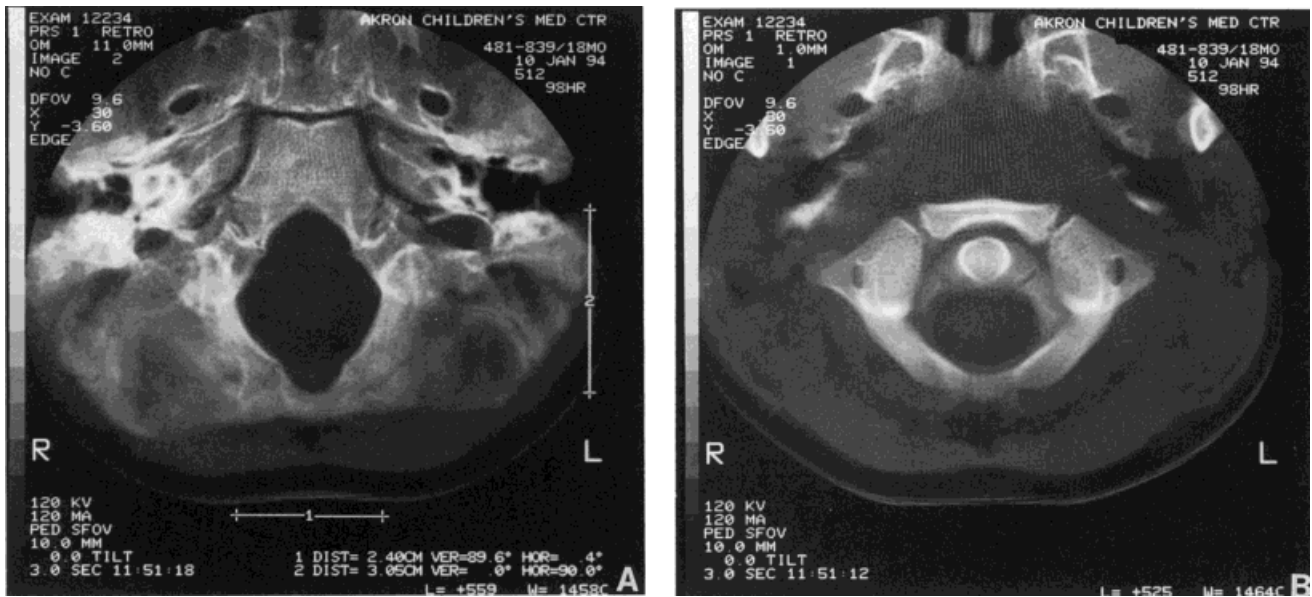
Six-month-old achondroplasia patient. A, B: CT of the skull revealing decreased side wall diameter of the foramen magnum and oval shape to the foramen magnum. In contrast, there is a normal C<sub>1</sub>C<sub>2</sub> diameter and shape at the odontoid level.
